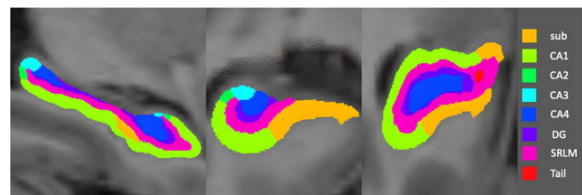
Segmented hippocampal subfields visualized on T1-weighted MRI images using the Hippunfol software. The image shows coronal, sagittal, and axial views of the hippocampus with color-coded labels for each subfield. Each color represents a distinct hippocampal subfield, facilitating detailed structural analysis and volumetric comparisons across different conditions. Sub: Subiculum, CA: Cornu Ammonis, DG: Dentate Gyrus, SRLM: Stratum Radiatum-Lacunusum-Moleculare, MRI: Magnetic Resonance Imaging
